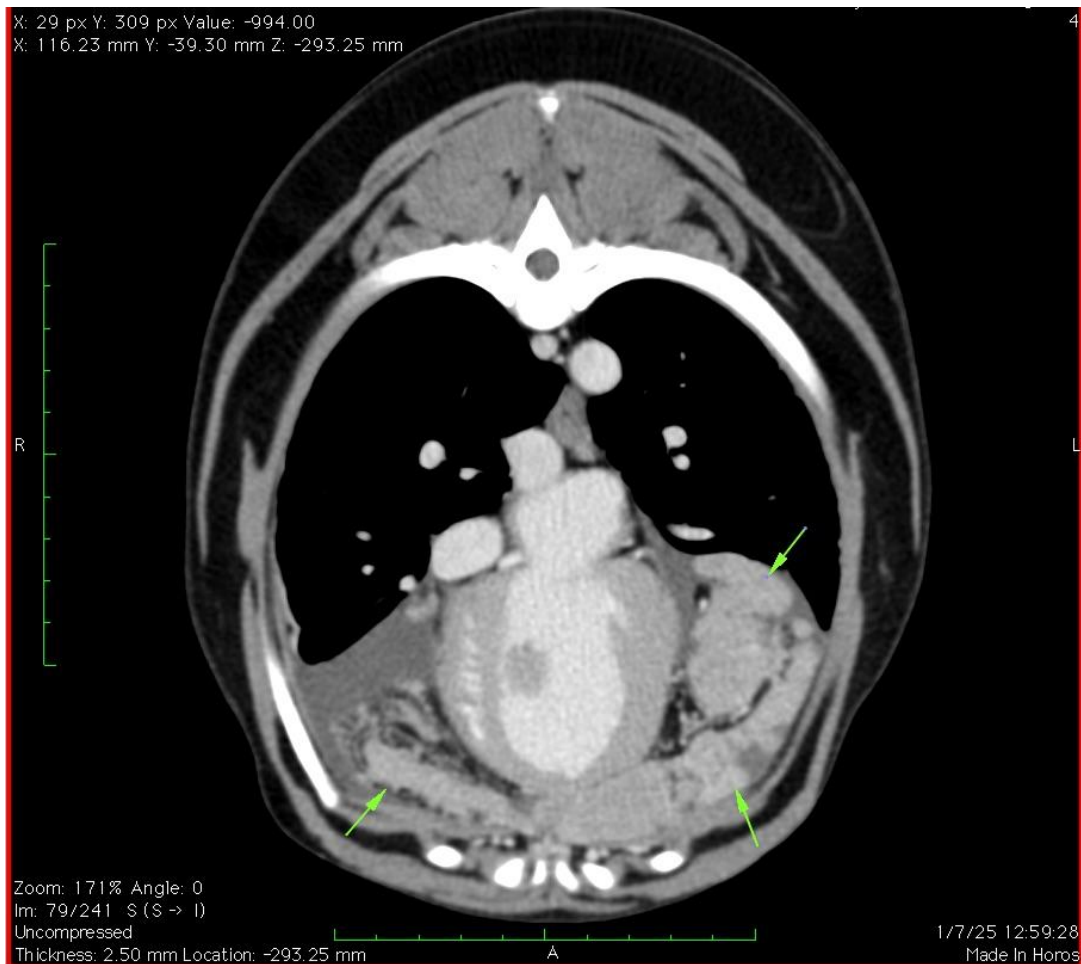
Thoracic CT scan demonstrating a large ventral mediastinal mass (green arrows).
